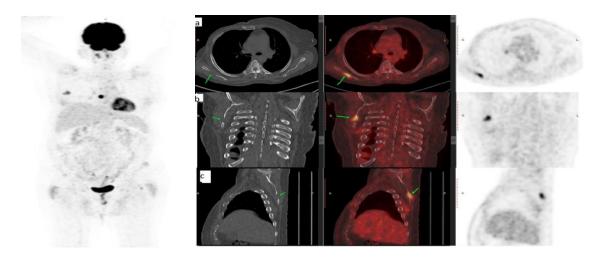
A 64 yrs.-old female with right breast cancer *PET/CT* (a: axial, b: coronal, c: sagittal) images showed lytic lesion at right scapula with metabolic parameters (SUV max 5.1, SUV mean 3.07, SUV peak 3.52, MTV 3.2, TLG 9.81)
